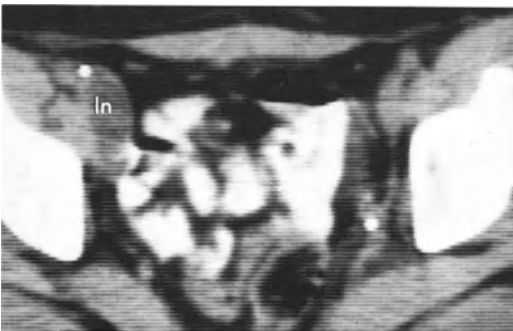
CT: cystic lymph node metastasis along external iliac vessels on right side. *ln*, lymph nodes
